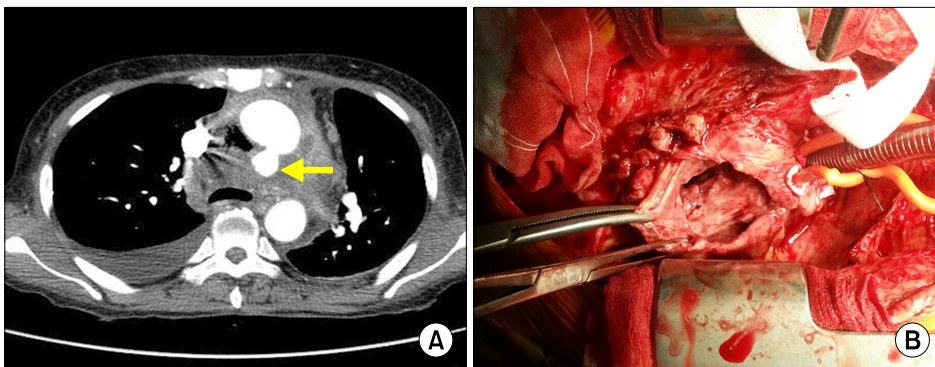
(A) A computed tomography image on the fifth hospital day shows a 2-cm pseudoaneurysmal sac at the distal ascending aorta (arrow). (B) A photograph taken during the second operation shows thick and purulent pericardium containing heavily organized necrotizing materials and hematomas.
